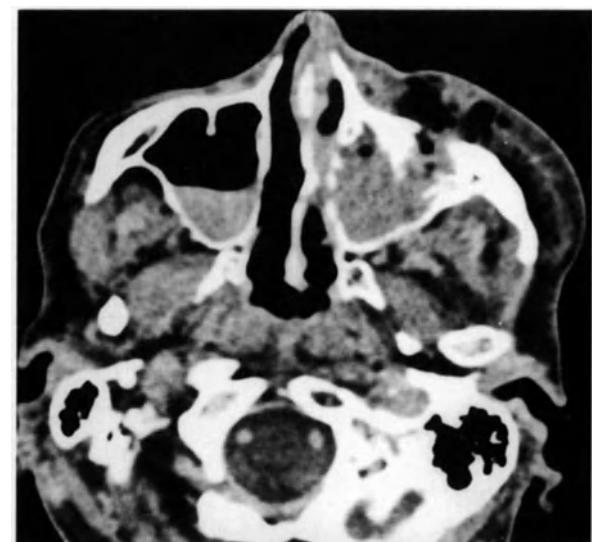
Axial CT slice through the mid face reveals findings of a tripod fracture with almost complete opacification of the left maxillary sinus, soft tissue swelling and subcutaneous emphysema. Fractures through the orbital rim and floor and lateral wall of the maxillary sinus are visible. A zygomatic arch fracture was visible on a cut 1 cm lower. No bony fracture to explain the air-fluid level in the right maxillary sinus was detected.
